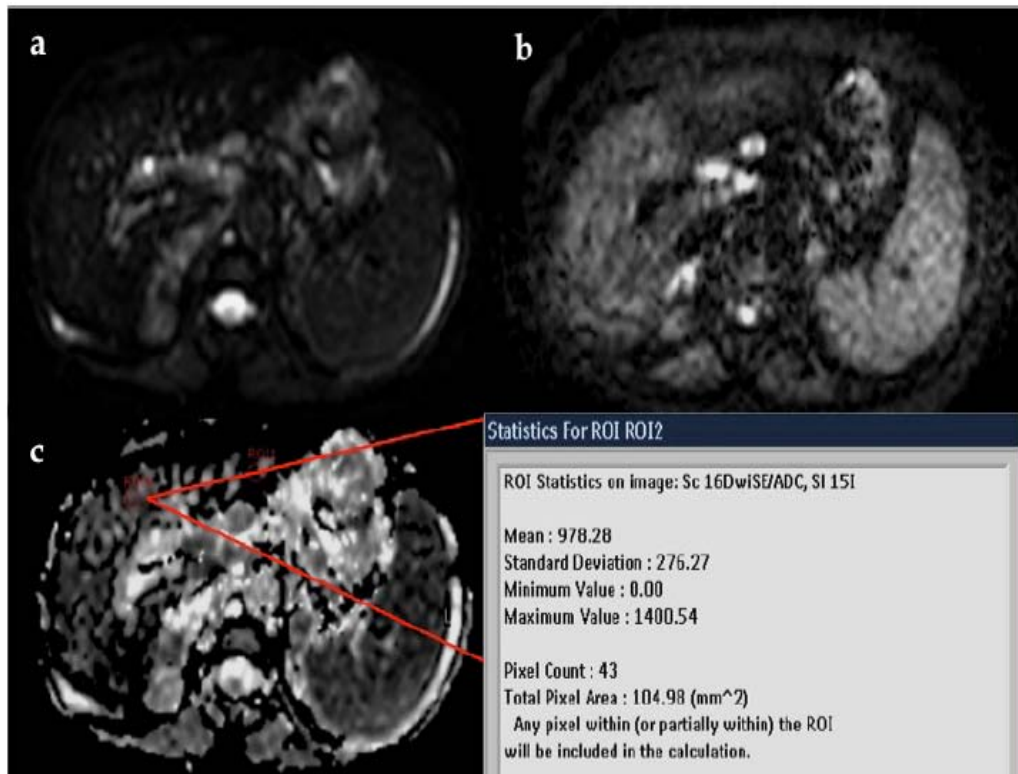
A patient with hepatitis C and related stage III fibrosis. DWI obtained with b value of 0 (a) and 800 (b) s/mm² and ADC map (c) are shown. Mean ADC value was 0.98×10^{-3} mm²/s.
